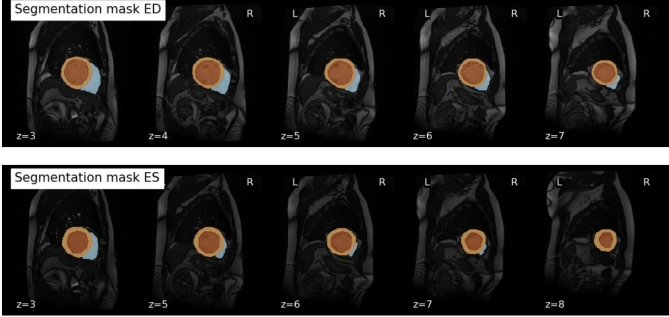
MRI images plus masks of different cuts
